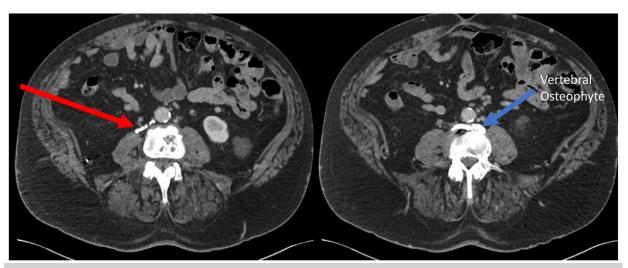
Transverse computed tomography venogram showing calcified thrombus directly inferior to the Adams-DeWeese clip (*red arrow*) within the suprarenal inferior vena cava (IVC), with total occlusion of the distal vena cava extending to the level of the bilateral iliac veins.
